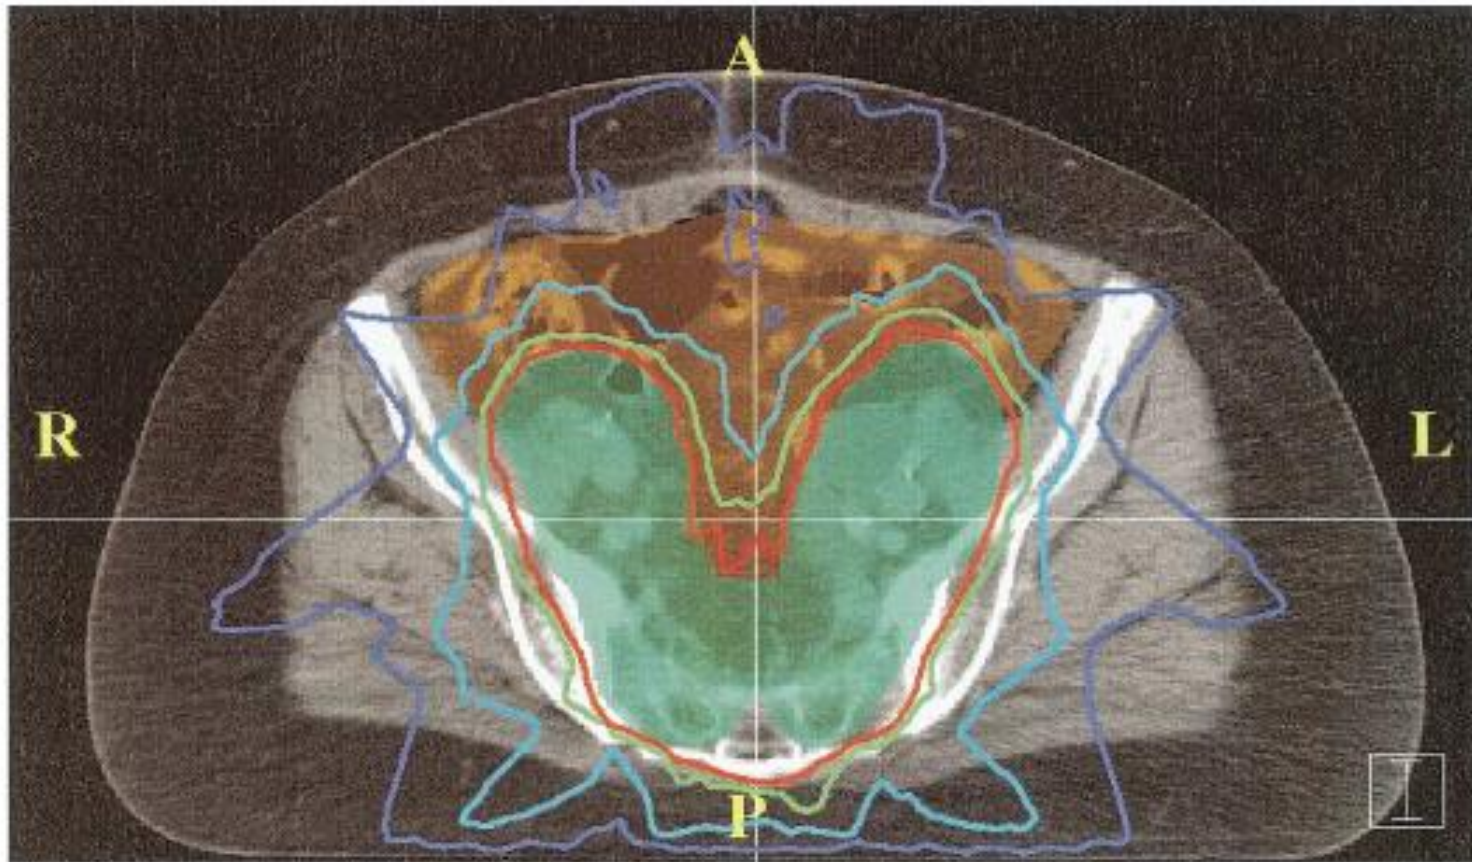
Isodose curves from an IM-WPRT plan superimposed on an axial CT slice through the upper pelvis. The small bowel and PTV are shaded in orange and green, respectively. Highlighted are the 100% (red), 90% (green), 70% (light blue), and 50% (dark blue) isodose curves.
